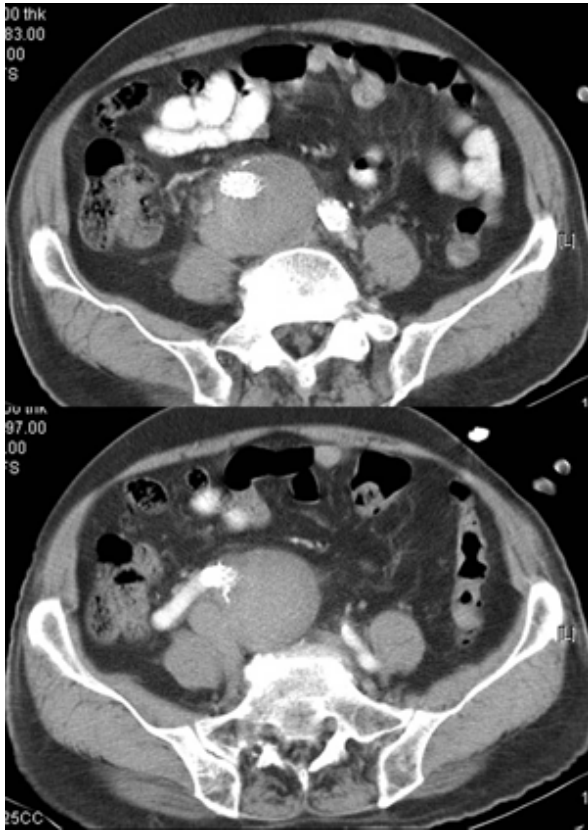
Follow-up pelvic CT scan revealed complete thrombosis in the aneurysm without endoleak.
